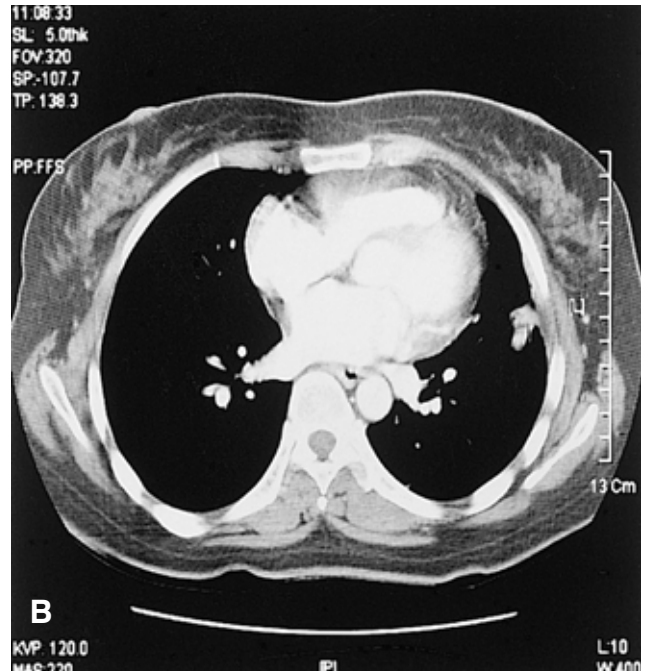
The chest CT scan shows that the tumor is markedly reduced after chemotherapy.
